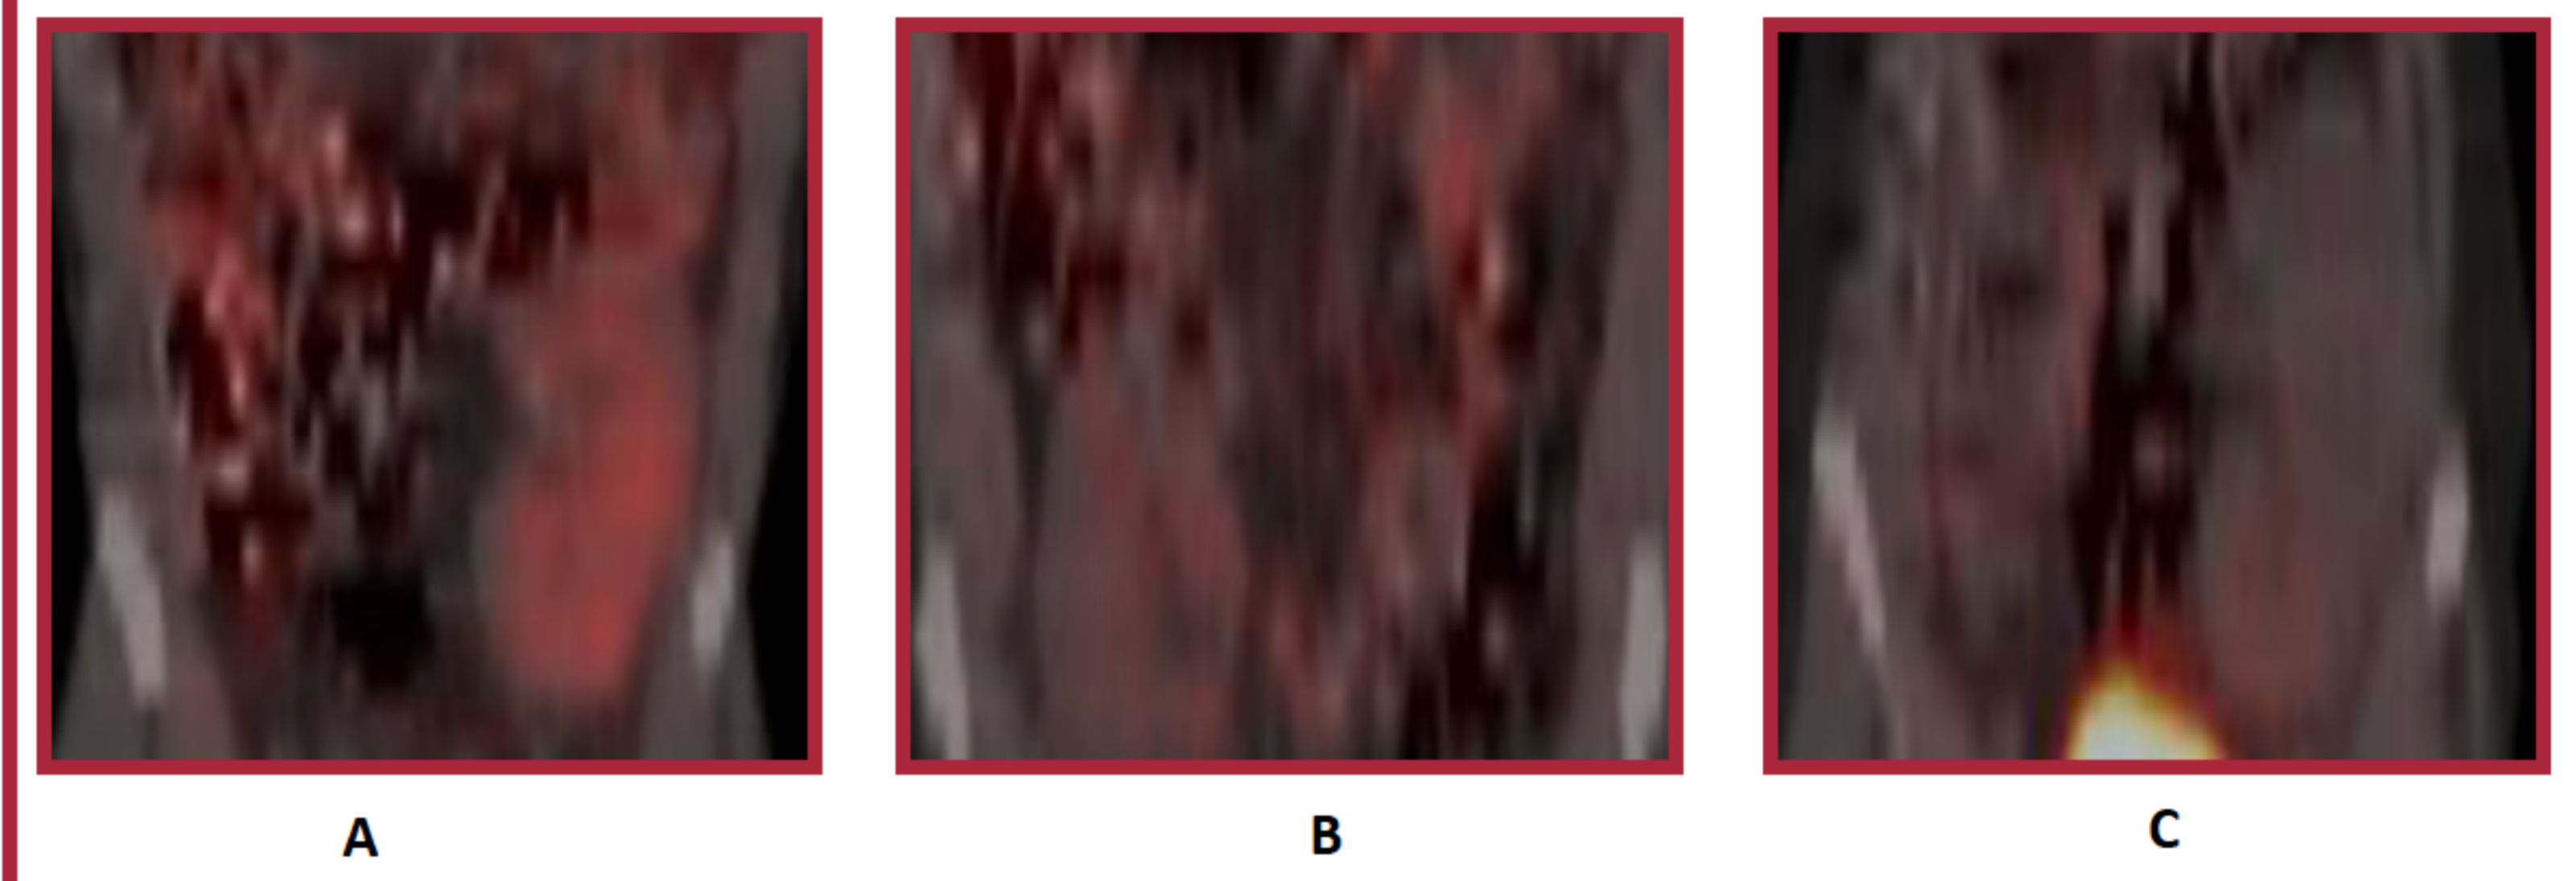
SPECT-CT ¹²³I-MIBG images of patients with various lengths of time after kidney transplantation.
